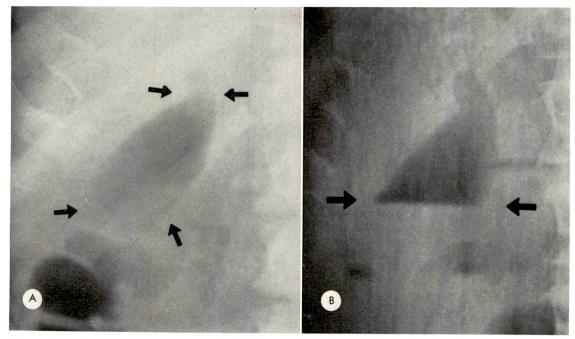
Emphysematous cholecystitis. (A) Pear-shaped radiolucency in right upper quadrant with tapered upper margin characteristic of neck of gallbladder. (B) Erect roentgenogram showing fluid level (arrows) outlined by gas in the upper half of gallbladder.
